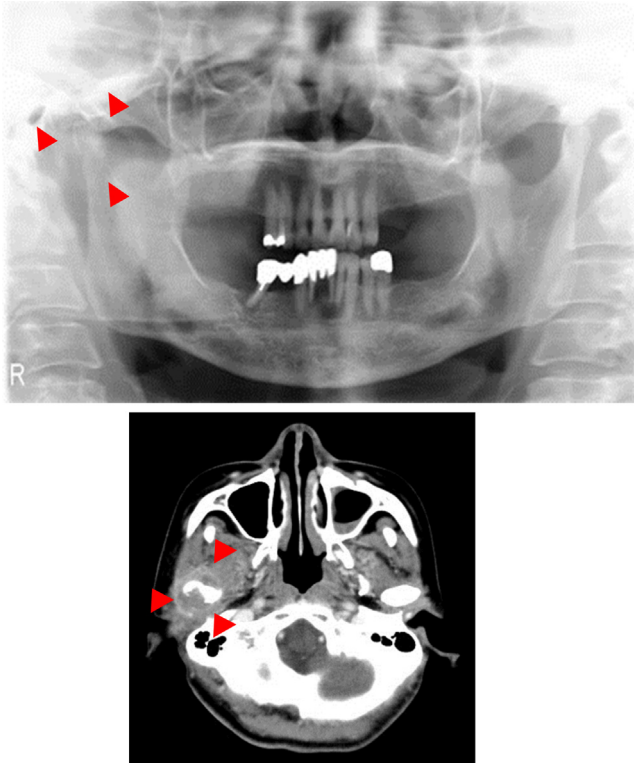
Initial X-ray images obtained in April 2008. Panoramic radiography (upper) and computed tomography (lower) showed bone destruction and tumor spreading around the right mandibular condyle. The tumor is indicated by the red arrowheads. The mass was located in the central portion of the mandibular condyle. (For interpretation of the references to color in this figure legend, the reader is referred to the web version of the article.)
